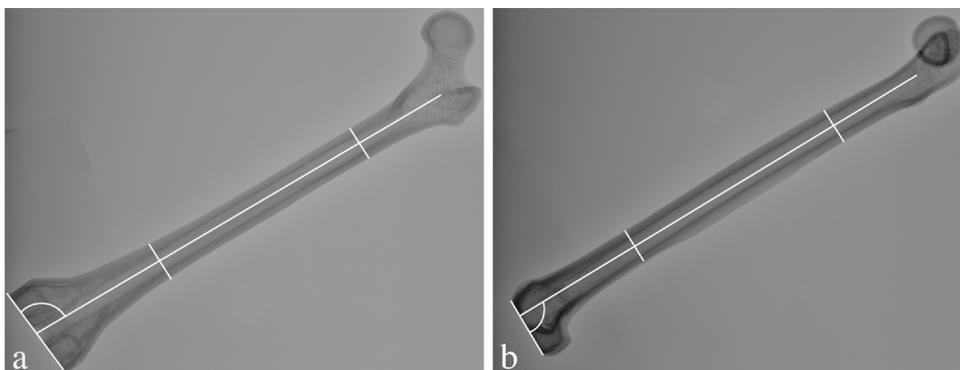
Plain radiographs of synthetic bone demonstrating the medial distal femoral angle (MDFA) in the anteroposterior view (a) and the posterior distal femoral angle (PDFA) in the lateral view (b).
